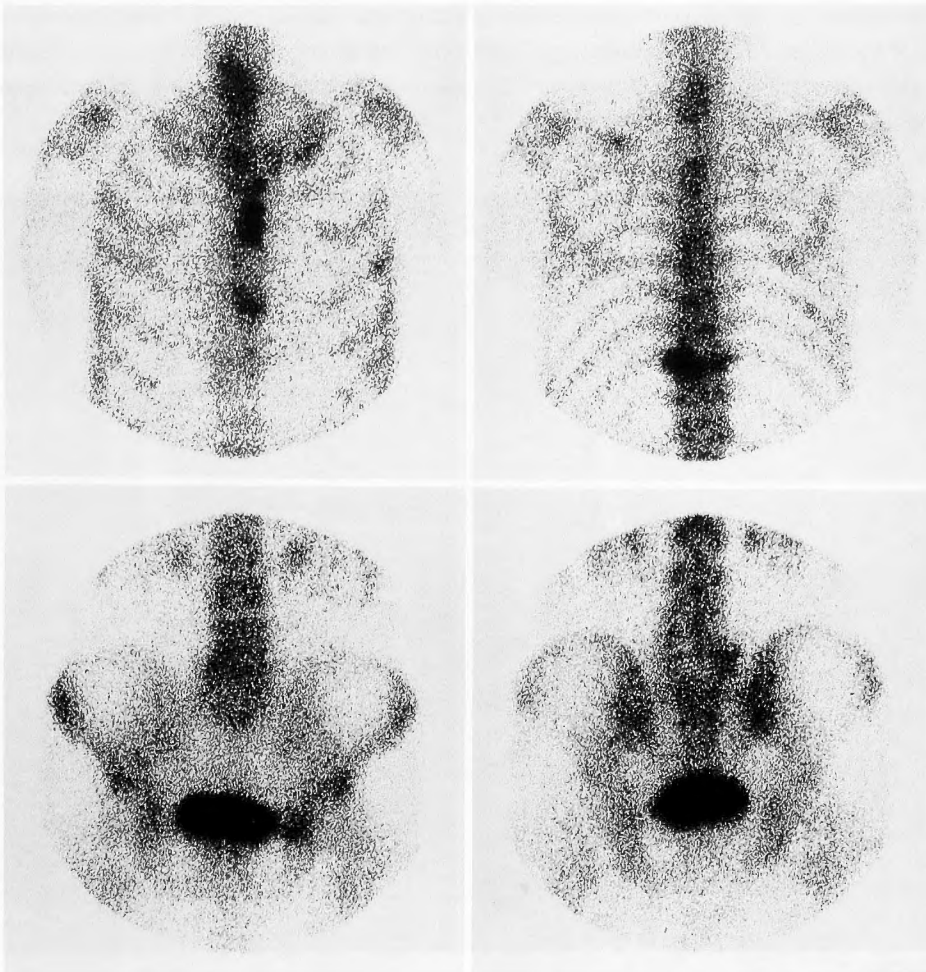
Bone scintigram in October 1992. Multiple isotope (^{99m}Tc)-uptake spots were detected.
